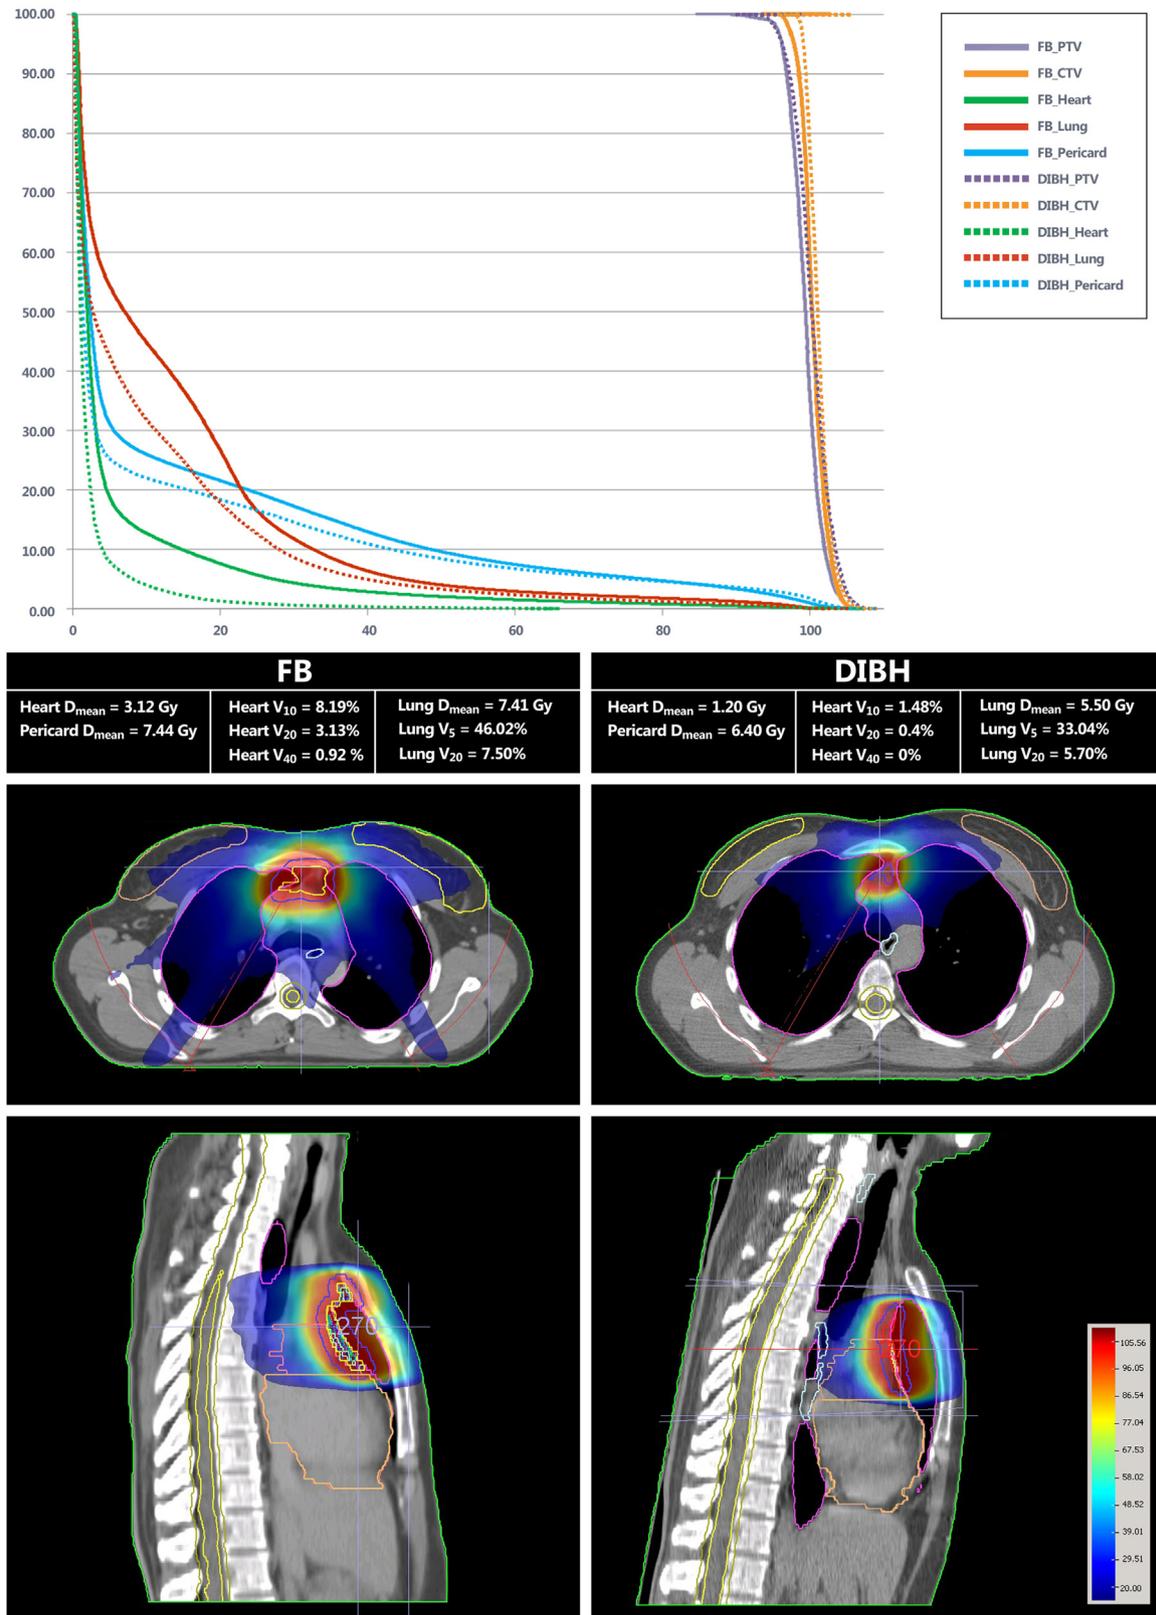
Free breathing (FB) VMAT plan and dose-volume histogram taking into account internal target motion based on 4D-CT scan versus deep inspiration breath hold (DIBH) VMAT plan in a 50-year old patient after R1 resection of thymoma.
